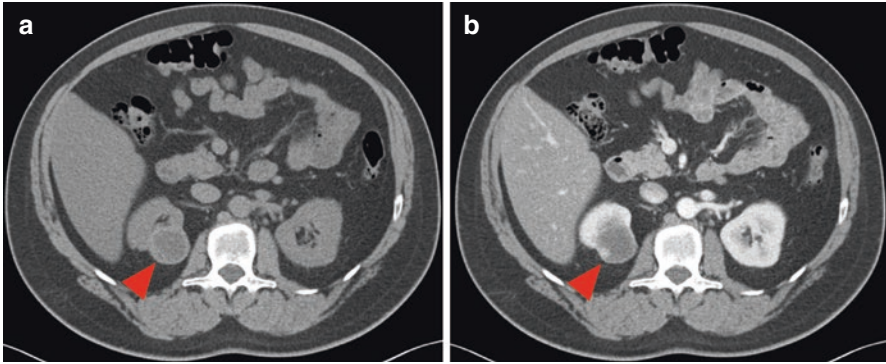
CT images of a Bosniak IV renal cyst. (a) Axial, non-contrast image of a predominantly low-density right renal lesion that does visually appear to be a simple cyst (red arrowhead). (b) Axial, venous phase CT demonstrates that much of the lesion does not enhance; however a nodular, enhancing component is present within the wall of this cystic lesion (red arrowhead)
